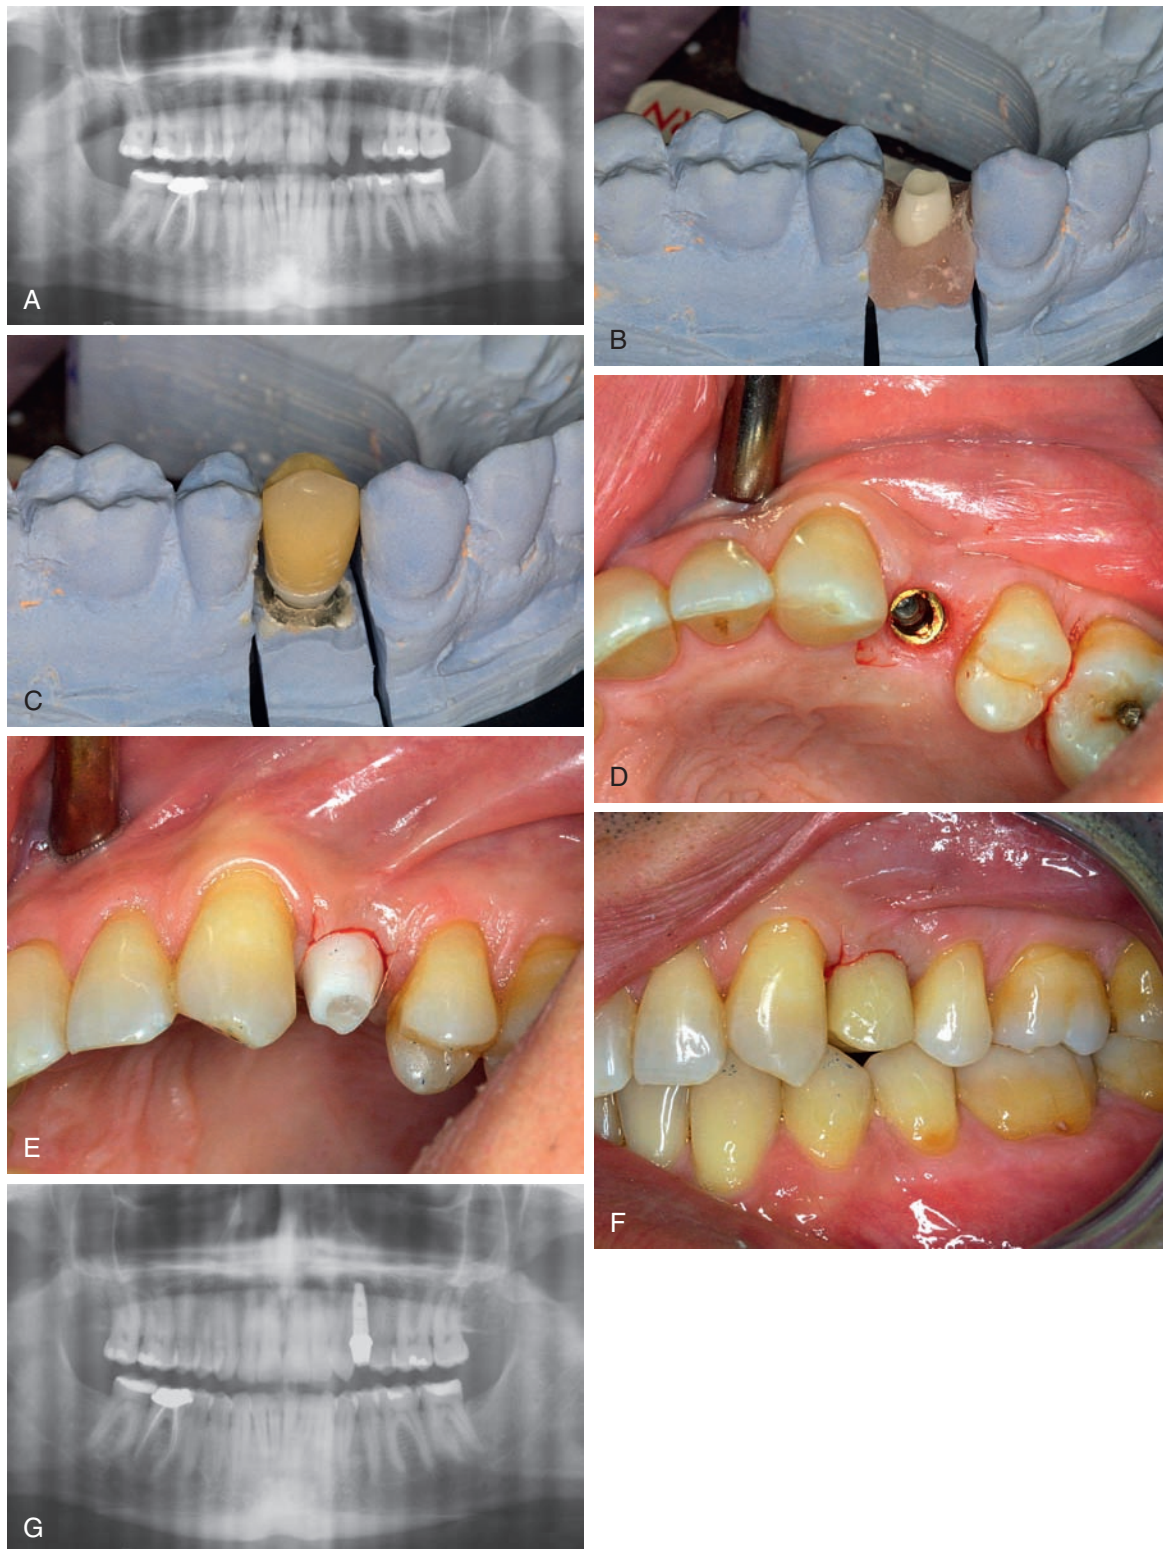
A, Panoramic radiograph of edentulous site (tooth #12). Note adequate bone height and density. B, Laboratory model with implant analog plated and fabricated final zirconia abutment. C, Laboratory fabricated provisional crown on final abutment. D, Guided surgical placement of implant (Noble Biocare, Yorba Linda, CA) based from presurgical model planning. E, Placement of the final zirconia abutment at the time of implant placement (torqued to 35 Ncm). F, Provisional restoration adjusted to modify occlusal load. G, Immediate postoperative panoramic x-ray. (B, C, and E-G, From Rosenlicht JL, Ward J, Krauser JT: Impressions at surgical placement and provisionalization of implants. In Fonseca RJ, et al, editors: Oral and maxillofacial surgery, vol 1, St Louis, 2009, Elsevier.)
